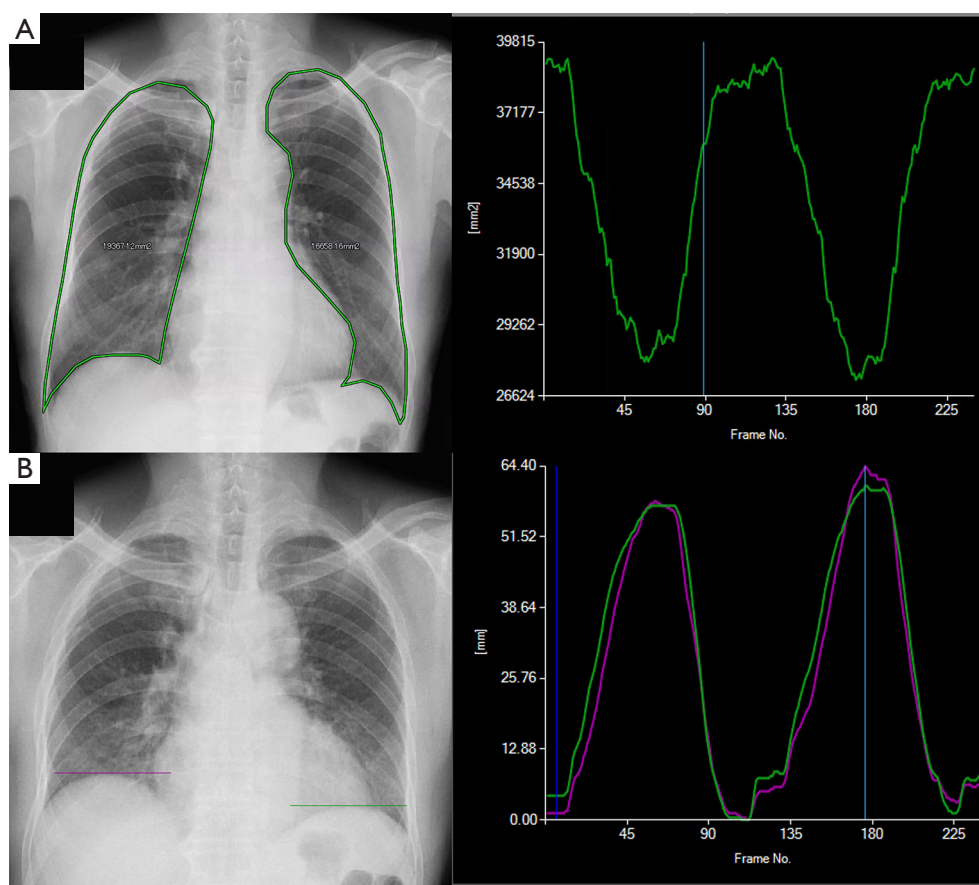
An example of the screen displayed at the dynamic chest radiography workstation. (A) Automatic analysis of the projected lung area. The areas of the right and left lung fields at each time phase are traced using a green frame, allowing dynamic observation of changes in the lung field area throughout a breathing cycle. The right side displays a graph showing changes in the projected lung area. (B) Dynamic analysis of diaphragmatic motion. The peak of the right diaphragm is indicated by a purple bar, and the peak of the left diaphragm by a green bar, enabling dynamic observation of diaphragmatic movement throughout a breathing cycle. The right side displays a graph showing changes in the excursion of diaphragm separately for the right and left diaphragm.
